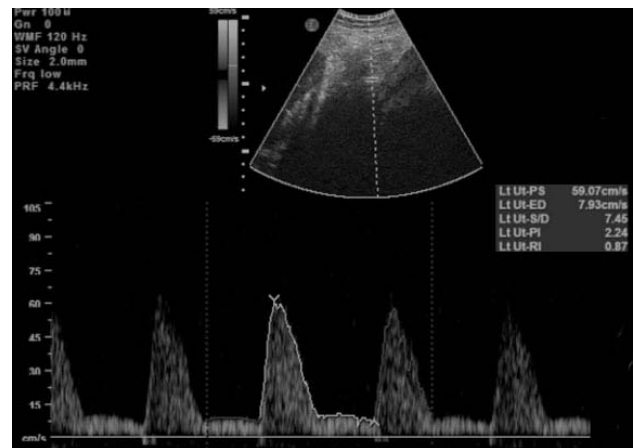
Abnormal uterine artery doppler waveform with high resistance flow
